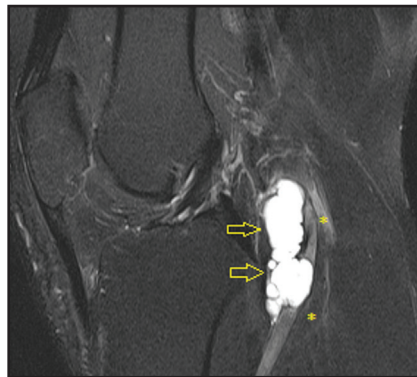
Sagittal T2-weighted image (TR 5650, TE 78) reveals a high signal multi-lobulated lesion (arrows) compressing the popliteal artery (asterisk).
